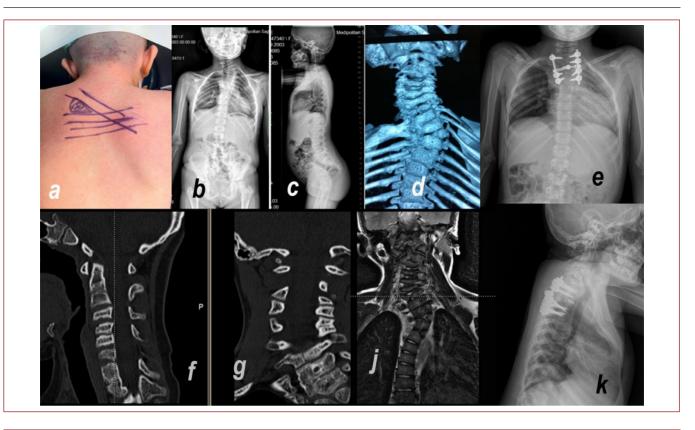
Patient Ş.A., a 10-year-old male, had an upper thoracic hemivertebra and a resulting upper thoracic 45° major deformity. a) Posterior view of the patient and planning, b) PA X-ray of the patient standing, c) lateral X-ray, d) 3D computerized tomography, e,f) computerized tomography images, g) frontal MRI, j,k) postoperative PA and lateral X-rays.
